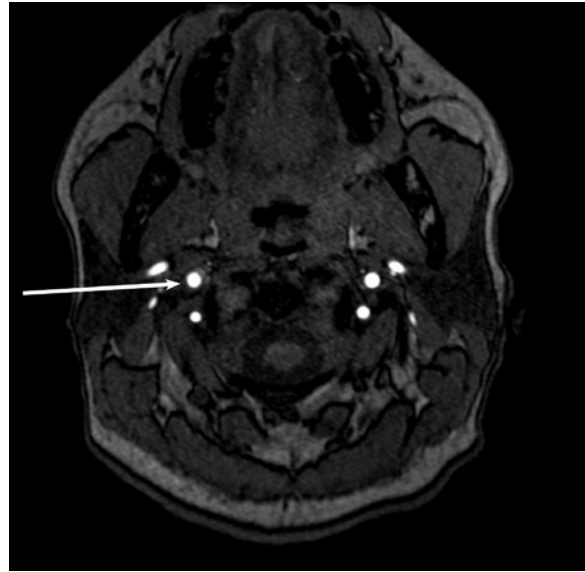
MRI (axial image) showing complete resolution of the stenosis and a small residual intramural haematoma around the area of the dissection.
